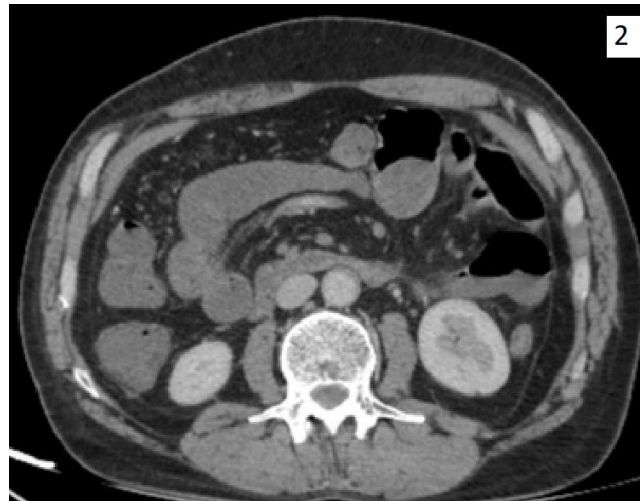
Axial CT angiography scan showing lack of enhancement of the intestinal wall, suggestive of intestinal ischemia
